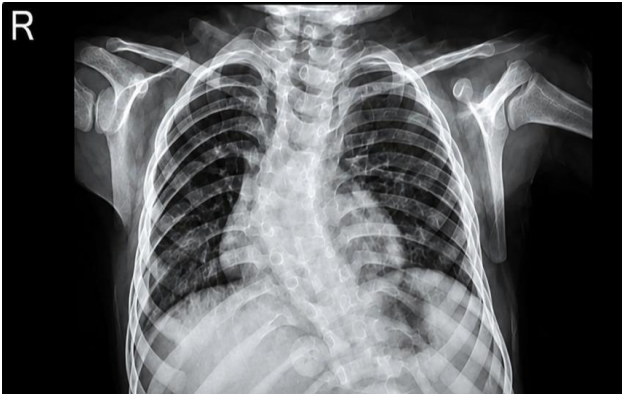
Case 3: X-ray of chest PA view of twin 2 showing scoliosis with convexity to right side.
